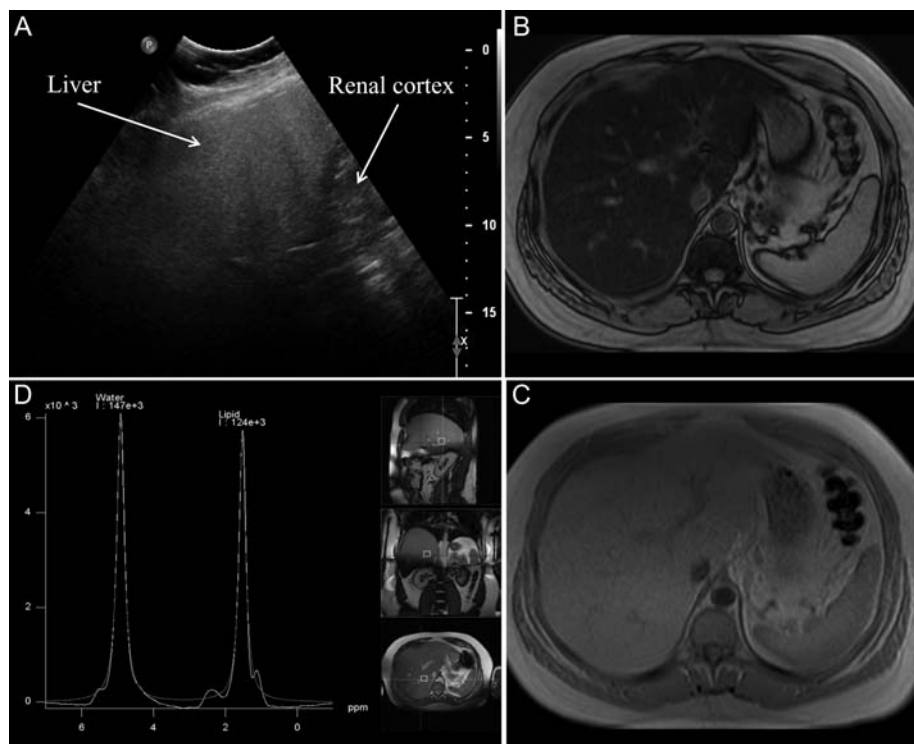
Liver imaging of a 35-year-old man with severe diffuse hepatic fatty infiltration. (A) Ultrasound scan showing diffuse increased echogenicity of liver parenchyma compared with renal cortex. (B) Chemical shift magnetic resonance imaging showing marked hepatic signal drop-off during out-of-phase image compared with in-phase (C) image, suggesting significant diffuse fatty liver. (D) Single-voxel magnetic resonance spectroscopy measuring area under lipid spectrum (second peak) relative to water spectrum (first peak), allowing accurate quantification of hepatic fat of 85% in the same patient.
